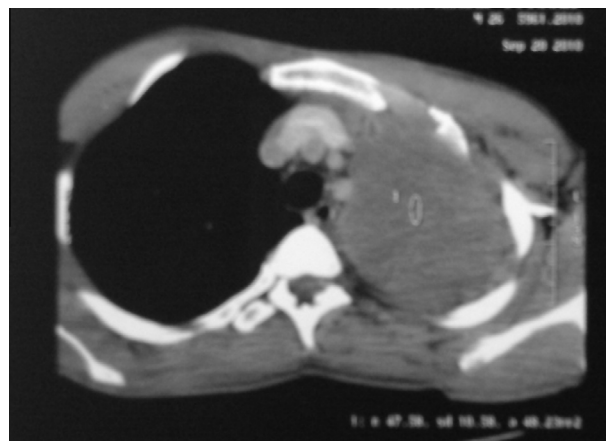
CT scan: left apical tissue mass.
